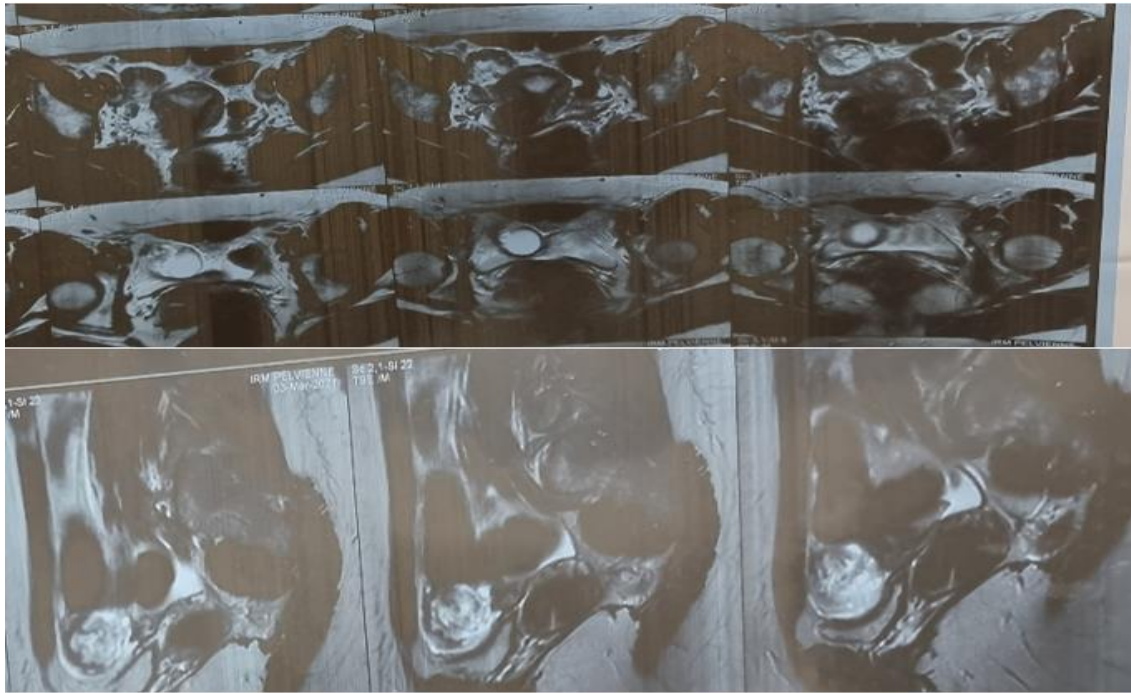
Pelvic MRI showing a right ovarian teratoma measuring 3,2/ 3,2 cm
